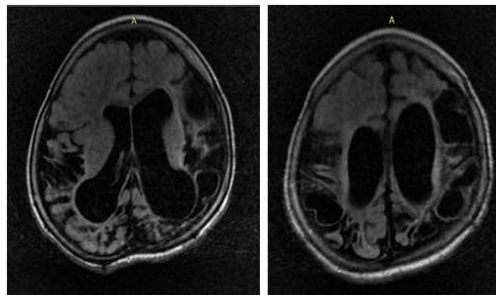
AXIAL FLAIR AXIAL FLAIR
